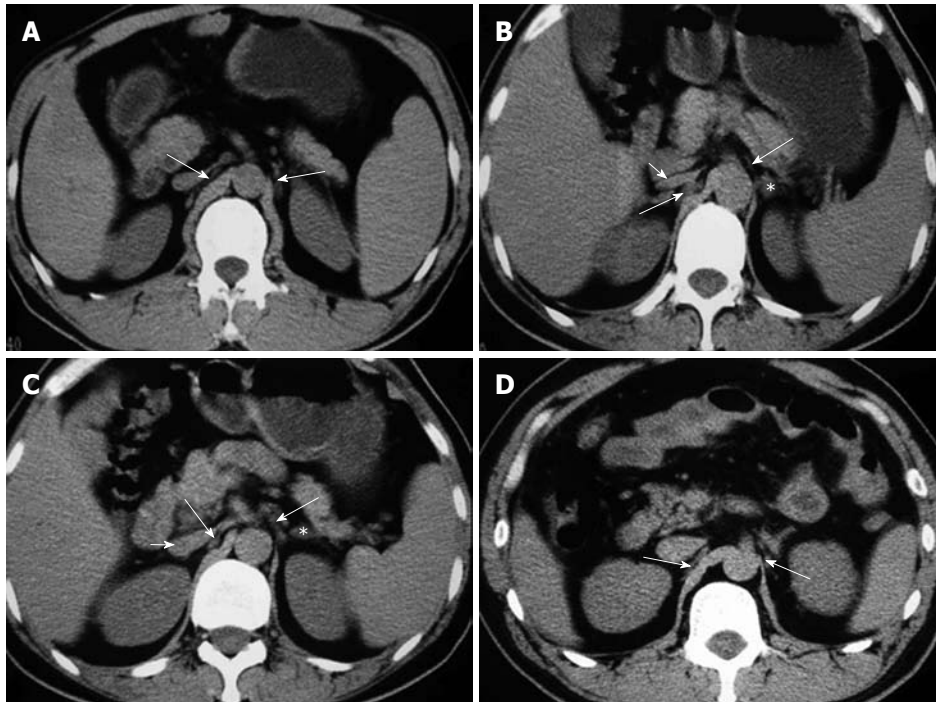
Computed tomography images show the celiac ganglia at different levels. A: A celiac ganglion (long arrows) at the root of the superior mesenteric artery; its density is the same as the liver and spleen or slightly less than the diaphragma crura; B: The celiac ganglia (long arrows) at the level of the pancreatic head and neck. The left celiac ganglia were lamina-shaped and located lengthwise in the space in the front of the left adrenal gland (*); the right celiac ganglia were a thick, line-shaped structure dorsal to the inferior vena cava (IVC) and lateral to the right diaphragma crura; C: A celiac ganglion (long arrows) at the level of the root of the celiac trunk. It appeared lamina- and nodule-shaped; D: The celiac ganglia (long arrows) at the level of the uncinate process, with well-defined margins. The left ganglia were lamina-shaped and located lengthwise in the space to the front and the left of the adrenal gland (*); the right ganglia were thick and line-shaped, located dorsal to the IVC and lateral to the right diaphragma crura. Short arrows indicate IVC (B, C).
